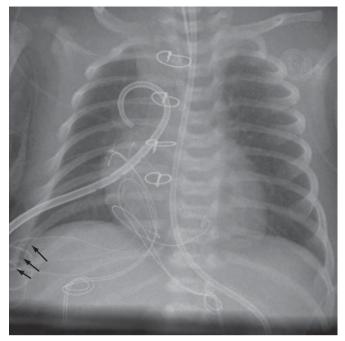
Pneumothorax in a supine patient. Chest radiograph demonstrates mild diffuse lucency in the right hemithorax and an asymmetrically deep right costophrenic angle (arrows) in a patient postsurgery for congenital heart disease.
